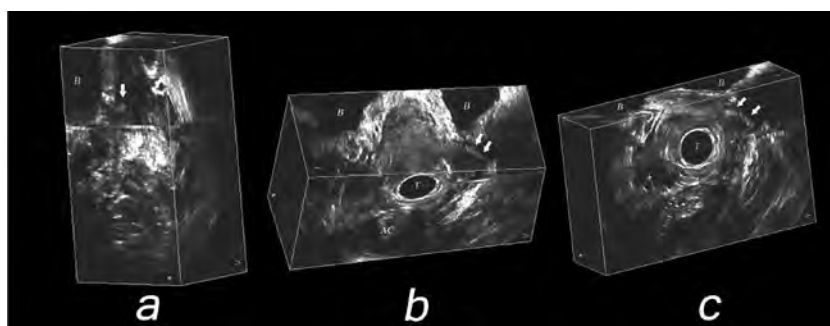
The sagittal (a), coronal (b), and axial (c) views of three dimensional ultrasound volume demonstrating a piece of sling (arrows). B indicates bladder; T, transducer; and AC, anal canal.
